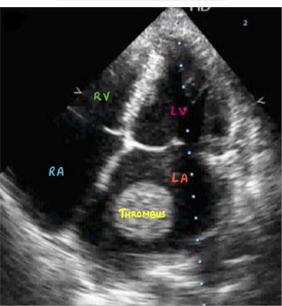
ECHOCARDIOGRAM FINDINGS SHOWING LA DILATION (LEFT) AND THROMBUS FORMATION (RIGHT).
